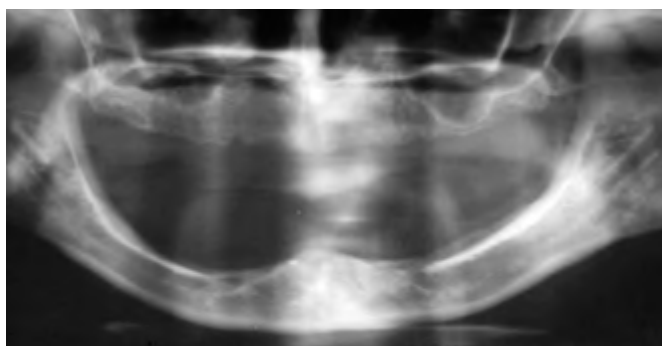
Initial panoramic radiograph that demonstrated moderate mandibular resorption in the anterior mandible and more significant resorption in the posterior mandibular quadrants.
